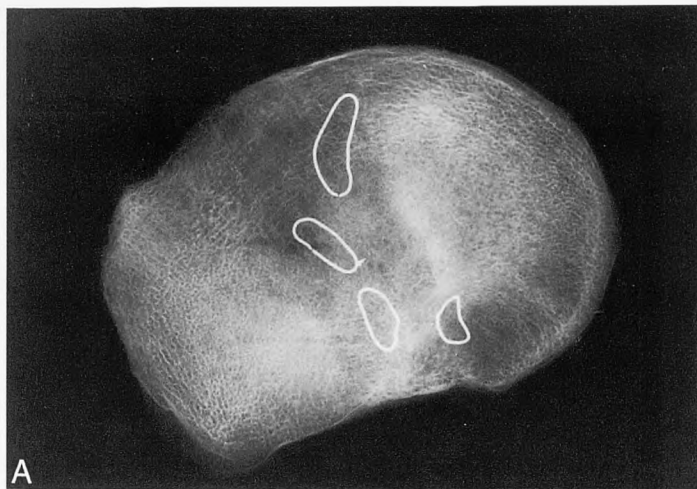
A, Radiographic anterior and posterior meniscal horn locations. B, Meniscal horn identification in relation to the lateral and medial meniscus (dotted outlines).
